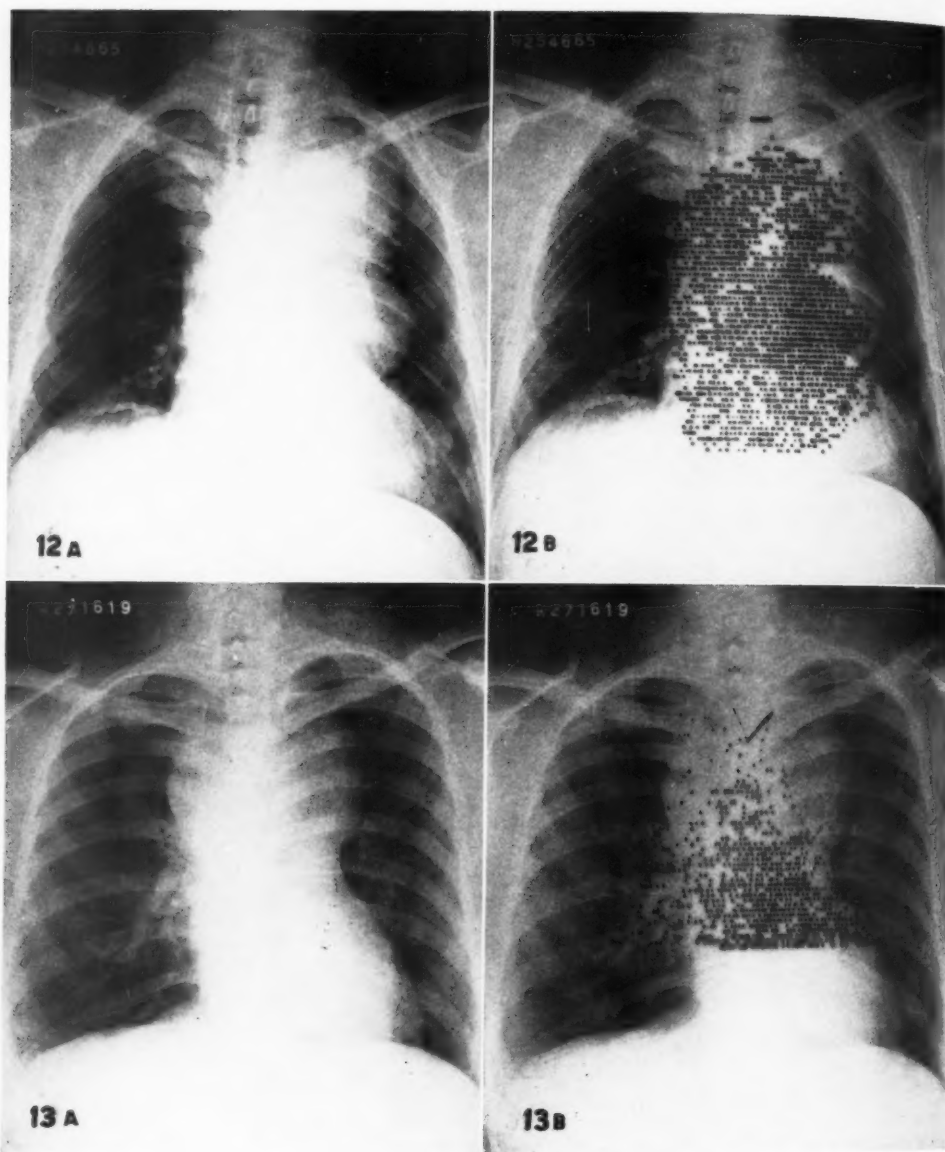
A. Postero-anterior roentgenogram of chest of patient with unusual widening of the mediastinum. B. Superimposed cardioscan corresponds with the mediastinal mass, consistent with aneurysm of the aorta. (Patient discussed in detail by Rejali, A. M., MacIntyre, W. J., and Friedell, H. L., *Am. J. Roentgenol.* 79: 129, 1958.)
